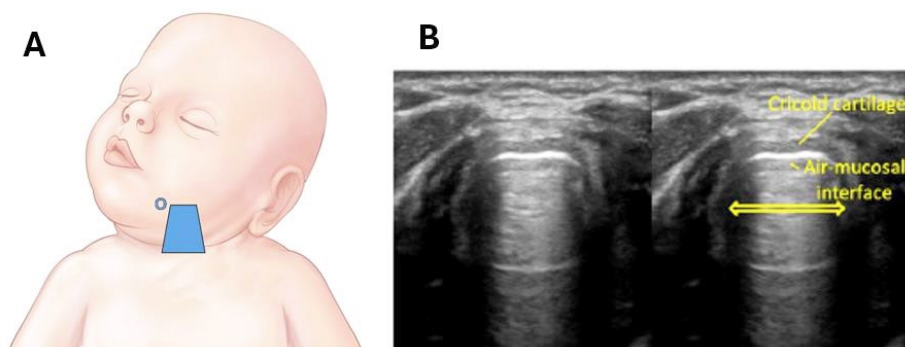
Airway ultrasound. (A) Placement of the ultrasound transducer with the orientation marker (o) towards the patient's right side with the neck in extension. (B) Transverse view of the anterior neck to measure tracheal diameter for appropriate endotracheal tube size. (adapted from Pan et al, 2023)
